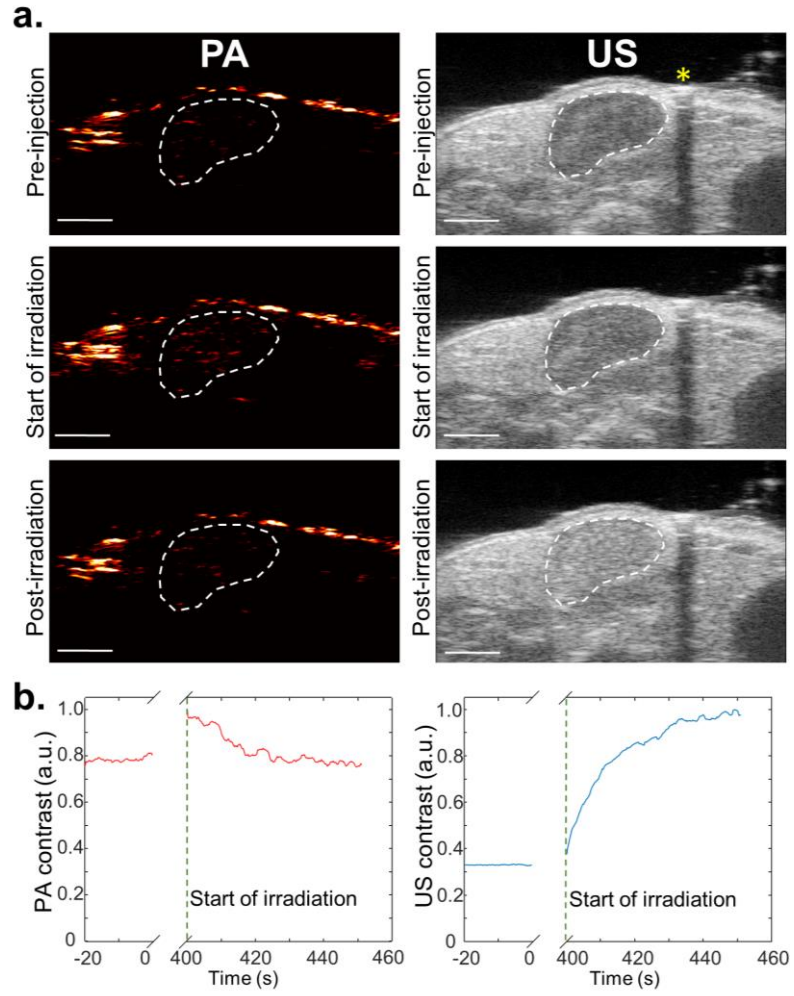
(a) Photoacoustic and ultrasound images of the lymph node before injection (top), after injection and upon starting laser irradiation (middle), and at the end of irradiation (bottom) show successful vaporization of CuS-PFCnDs and increased photoacoustic and ultrasound contrast throughout the lymph node. The yellow star denotes a bubble used as a marker for ensuring the same 2D imaging plane was maintained before and after injection. (b) Changes in photoacoustic and ultrasound contrast prior to CuS-PFCnD injection and then after injection at the start and end of the laser irradiation period. The photoacoustic and ultrasound contrast seen after irradiation are similar to observations in tissue models. Scale bars = 2 mm.
